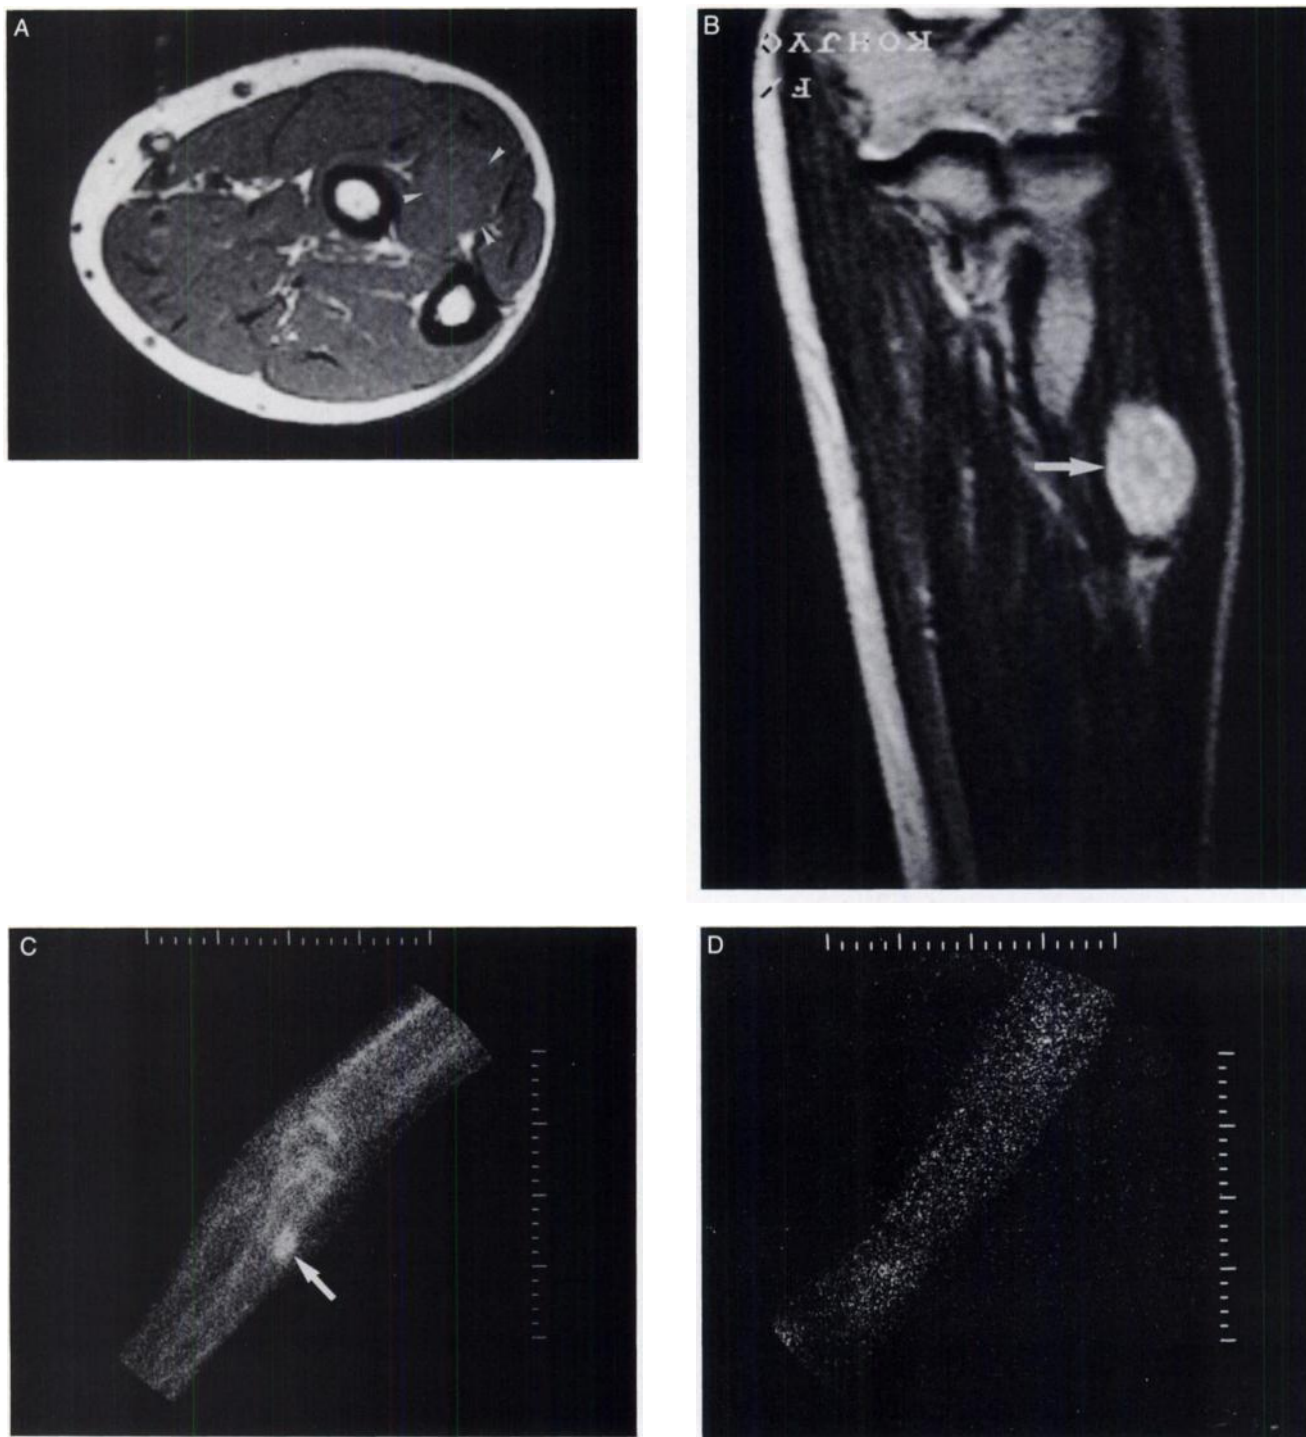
(A) (Patient 2). T1-weighted MRI shows a 2-cm round isointense tumor (arrow) in the left forearm. (B) On T2-weighted MRI, the tumor (arrow) is slightly hyperintense to subcutaneous fat. (C) A posterior spot $^{99m}\text{Tc(V)}$ DMSA scintigram shows accumulation in the tumor (arrow). (D) A posterior spot ^{67}Ga -citrate scintigram shows no accumulation in the tumor.
